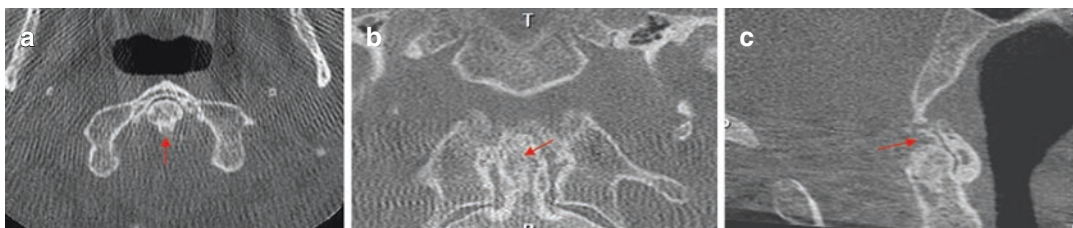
Axial (a), coronal (b), and midsagittal (c) CBCT images of a 66-year-old woman with moderate OA showing a nodule of calcification within and narrowing of intervertebral space between C2 and C3
